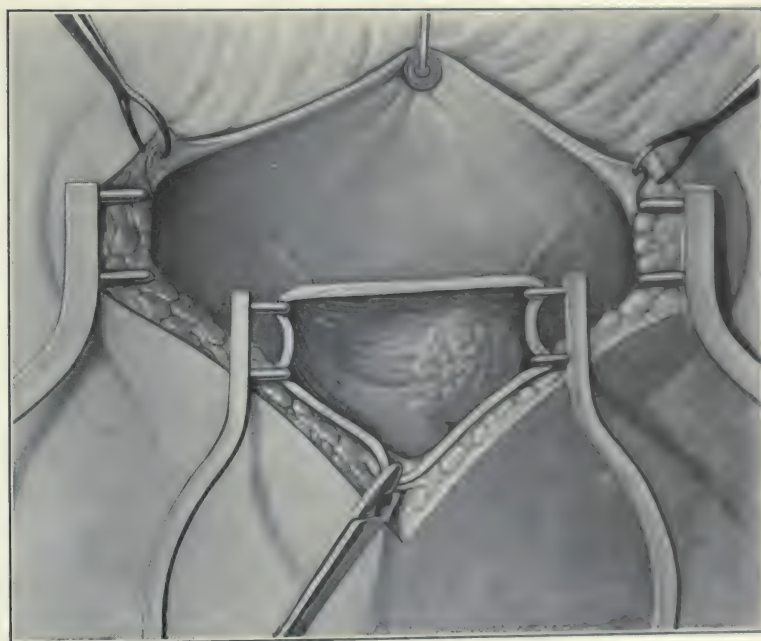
THE LONGITUDINAL INCISION IN THE BLADDER ENLARGED DOWNWARD TOWARD THE TRIGONE FOR MORE THOROUGH INSPECTION AND ORIENTATION.
